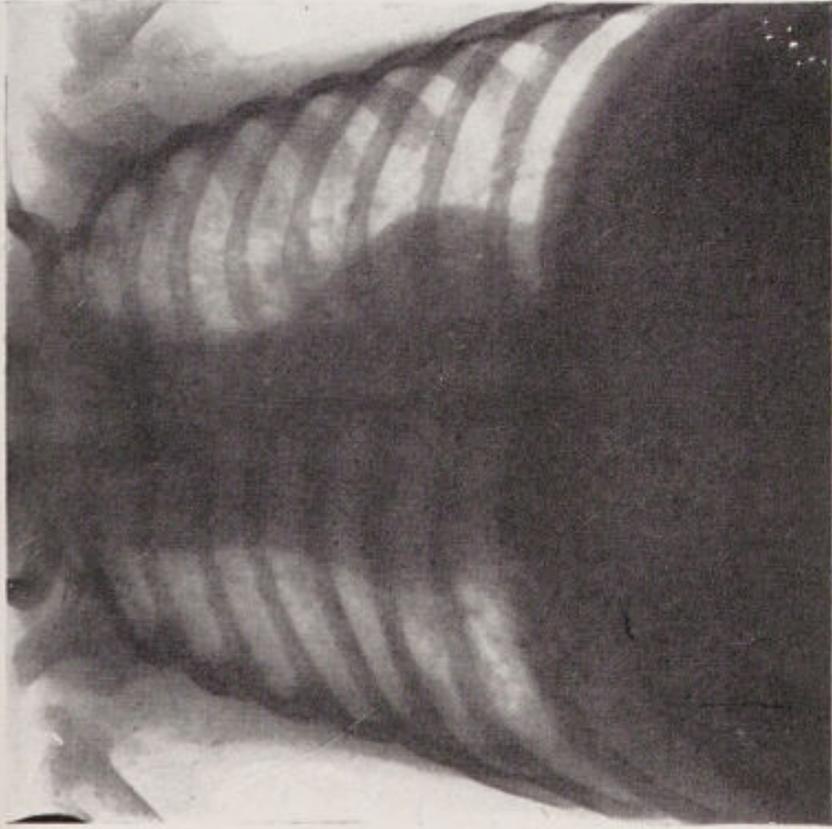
March 30, 1939; aged 7 months (15 days before death). Caseous pneumonia in right mid zone; whether due to liquefaction of primary focus or bronchogenic aspiration pneumonia cannot be decided from the radiograph; clinically the former is more likely. Commencing spread to left upper zone.
